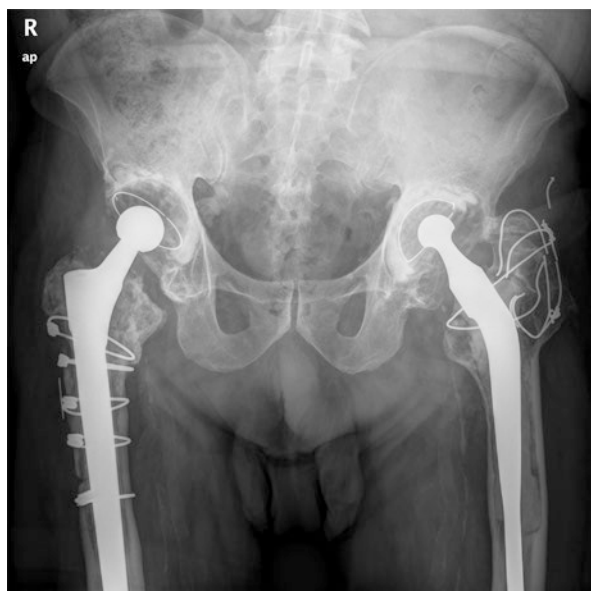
Anteroposterior radiograph of pelvis shows bilateral revised cemented total hip arthroplasties. Radiolucent lines around both components are clearly visible in both prostheses
